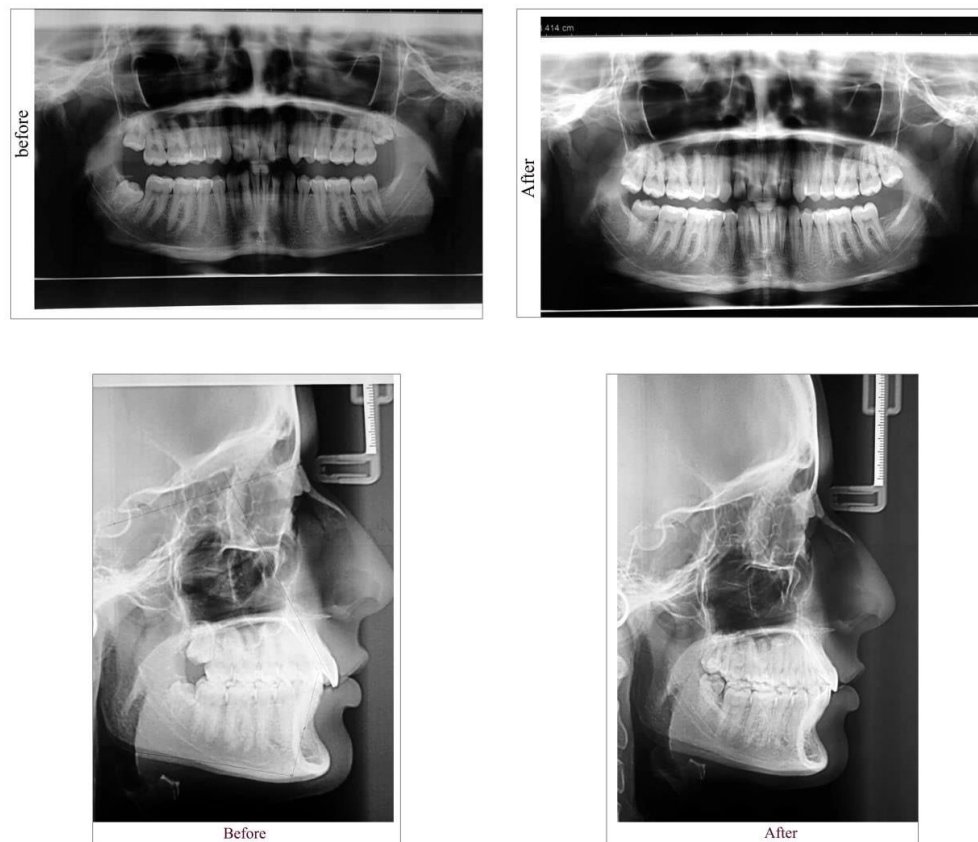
(Case V): Before and after treatment radiography in a 20 years old girl
